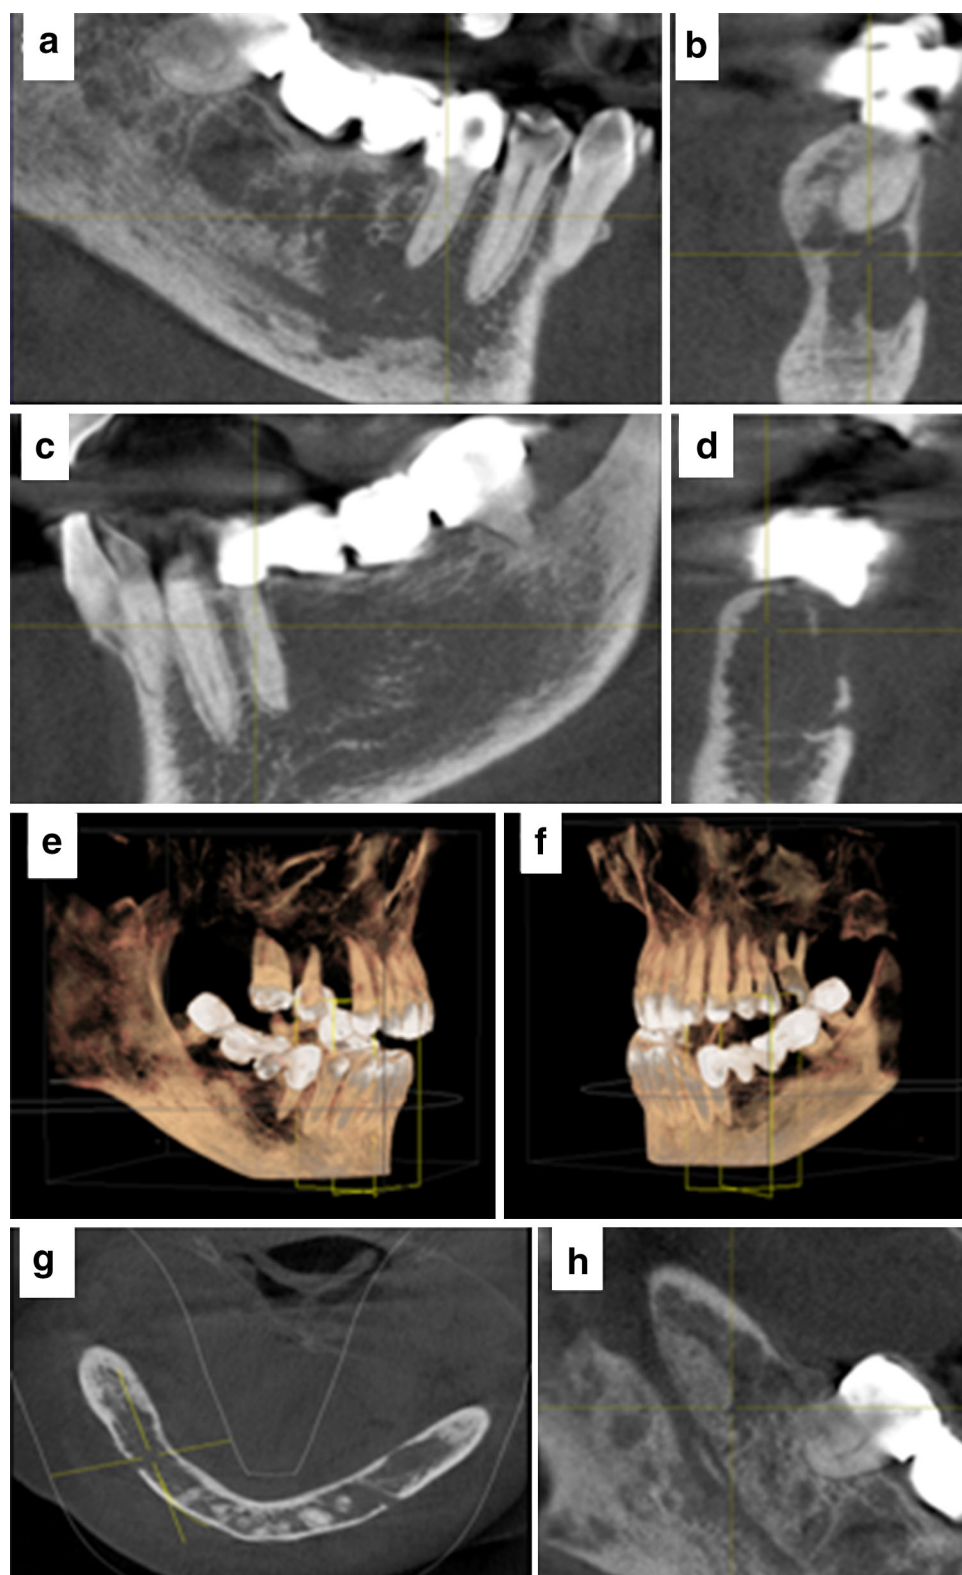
Cone-beam computed tomography scan of the jaw bones. a, b Cross-sectional and sagittal views of the poorly defined osteolytic lesion on the *right side* of the mandibular body. c, d Cross-sectional and sagittal views of the poorly defined osteolytic lesion on the *left side* of the mandibular body. e, f Three-dimensional volume images of the *right* and *left* affected sites in the mandibular body show
